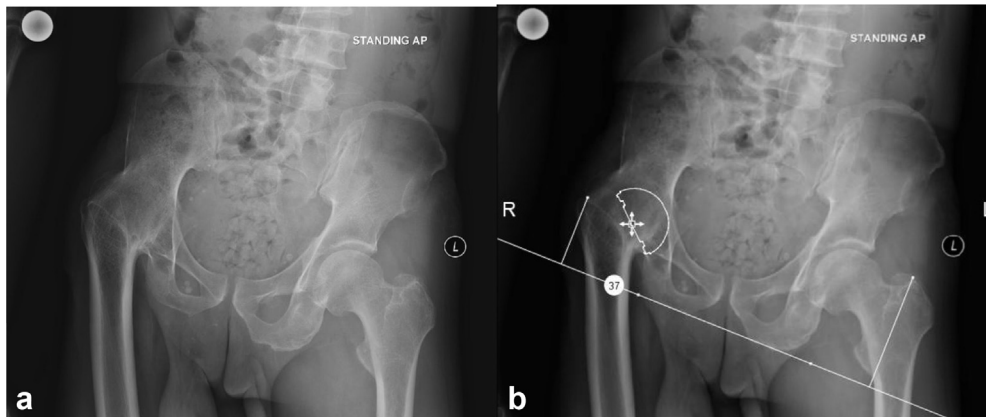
(a) Anteroposterior pelvic radiographs demonstrating complete ankylosis of the right hip. (b) Preoperative templating demonstrating an approximate 37-mm hip leg discrepancy, templated with OrthoView (Materialise Software; Plymouth, MI).
